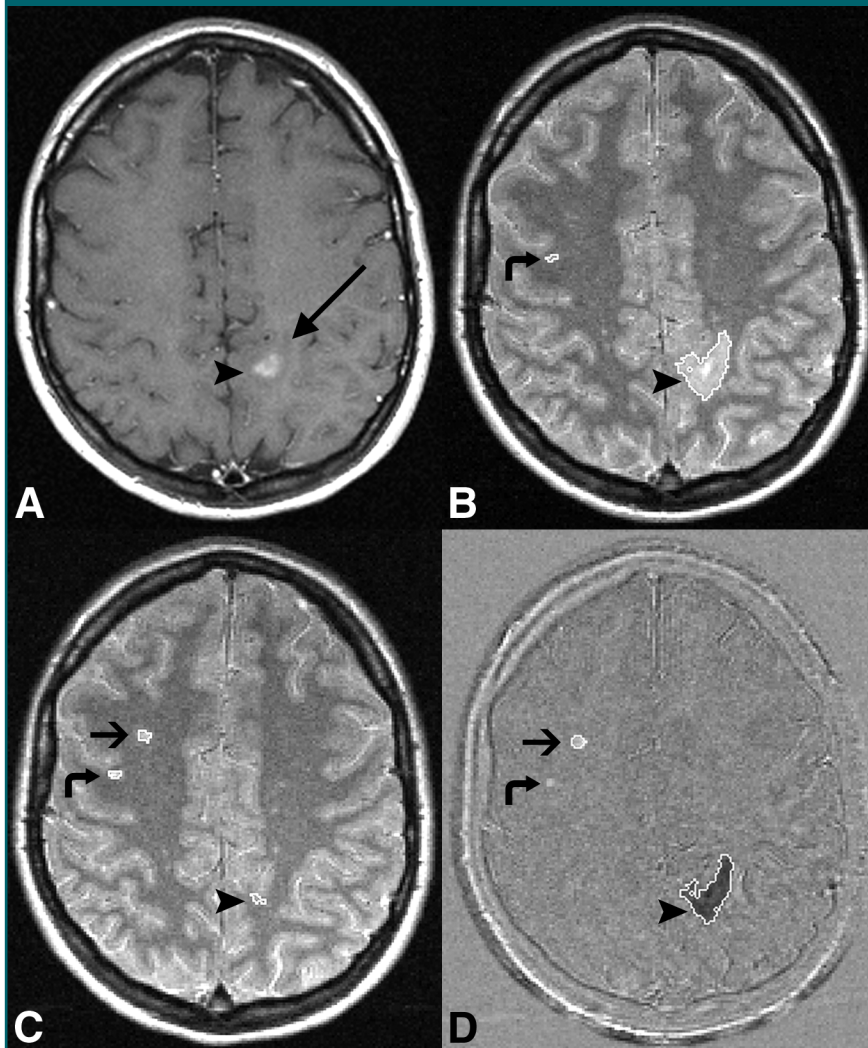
MR images show a large lesion load of negative activity relative to positive activity, possibly confounding detection of treatment effect. *A*, Native baseline gadolinium-enhanced T1-weighted image (400–700/5–25). *B*, Native baseline, *C*, native follow-up PD-weighted and, *D*, subtraction images with lesion outlines overlaid. Enhancing lesion (arrowheads) on *A* and *B* surrounded by edema (long arrow), which has been resorbed on *C*. Short arrows = new lesion on *C* and *D*. Curved arrows = false-positive positive activity on *D*, as the lesion was visible on *B* and *C* and did not increase in size.
